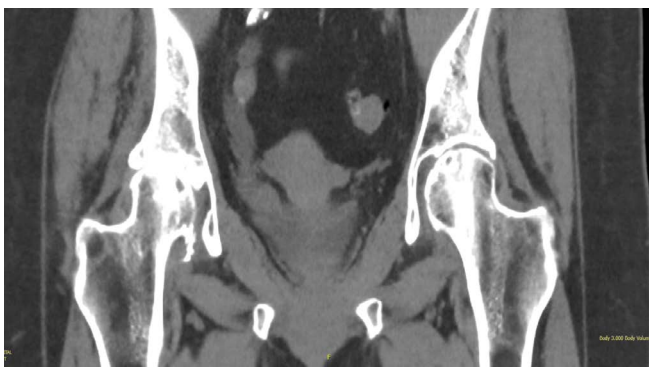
CT image showing lesion along right of distal ureter.
